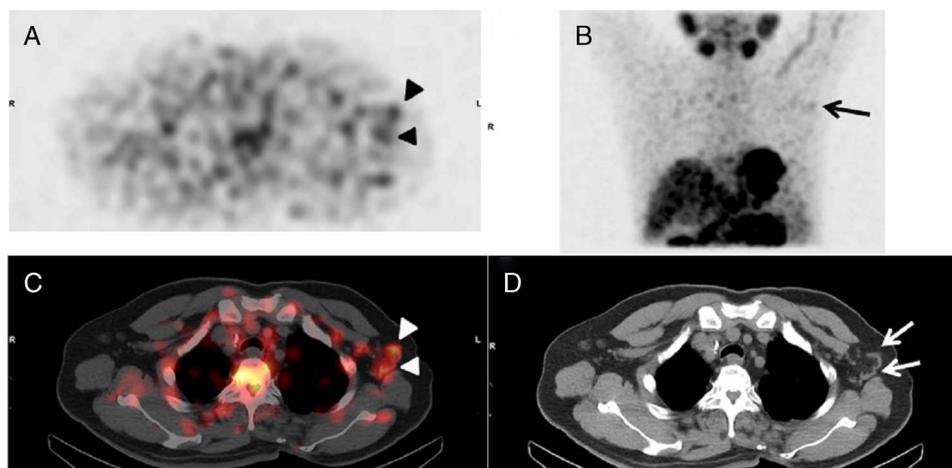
A 71-year-old man with known thyroid cancer status post total thyroidectomy and ^{131}I ablation in 2012 and right renal cell carcinoma status post right partial nephrectomy in January 2018 under posttreatment follow-up was presented. He also has hypertension and hyperlipidemia on treatment. He felt persistent chest tightness and chest pain after the first dose of the Moderna COVID-19 (mRNA-1273) vaccine. He was referred for a myocardial perfusion imaging (MPI) examination due to suspicious coronary heart disease. MPI results showed unlikely myocardial ischemia. However, ^{201}Tl -avid focal uptake was found incidentally over the left axillary region on MPI SPECT (A, black arrowhead) and MIP images (B, black arrow). Because of his previous cancer history, SPECT/CT was arranged, which revealed a cluster of lymph nodes in the left axilla (C, transaxial slice, white arrowhead; D, transaxial slice, white arrows), the largest one is 1.5 cm in diameter. Because the patient received a Moderna COVID-19 vaccine in the left upper arm 6 days ago, reactive axillary nodes ipsilateral to the intramuscular injection site are more favored than lymph node metastasis. COVID-19, caused by SARS-CoV-2 infection, is a global pandemic. The course of the disease could range from asymptomatic to death. Moderna, using mRNA biotechnology, is one of COVID-19 vaccines with Emergency Use Authorization. According to SNMMI statement, reactive lymphadenopathy has been reported approximately 16% of the patients who received COVID-19 mRNA vaccines.¹ Previous reports have showed that axillary lymphadenopathy was found on FDG PET/CT after various vaccines injection.²⁻⁵ Lymph nodes are mostly affected in an intramuscular site of ipsilateral deltoid vaccination seen on FDG PET/CT; however, contralateral lymph nodes may also show FDG uptake.⁶ Instead of FDG and ^{201}Tl , COVID-19 vaccines can lead mild accumulation of some other tracers that was issued in published articles.⁷⁻⁹ Nevertheless, it is sometimes limited and confused for evaluating between malignancy and inflammatory disease in breast cancer, lymphoma, or melanoma.¹⁰ By this case, we report a very rare imaging on ^{201}Tl MPI of incidental finding axillary lymphadenopathy after 6 days of COVID-19 vaccination. With the increasing rate of COVID-19 vaccination in present day,¹¹ a careful review of the clinical record and raw data of imaging is necessary for interpretation of axillary lymphadenopathy, especially in patients with cancer history.
